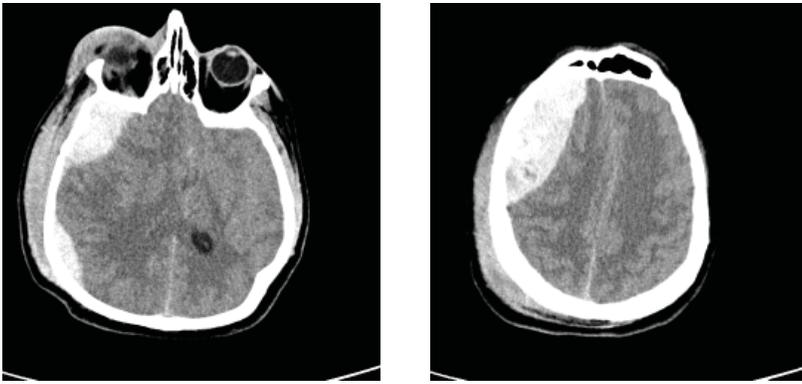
Follow up CT Brain done 6 hours later when the patient deteriorated clinically. (a) Larger right temporal and occipital acute EDHs with complete obliteration of the ipsilateral ventricle from the mass effect. (b) Enlargement of the right frontal EDH with significant midline shift
